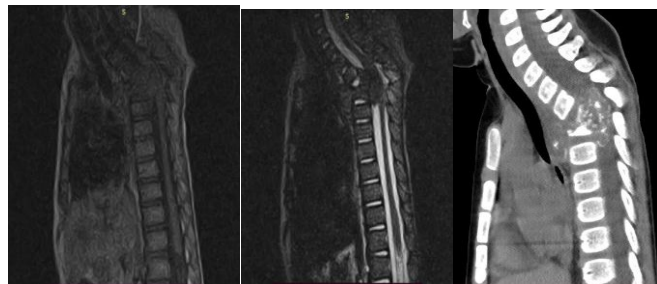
Preoperative MRI and CT images (spinal cord compression).
